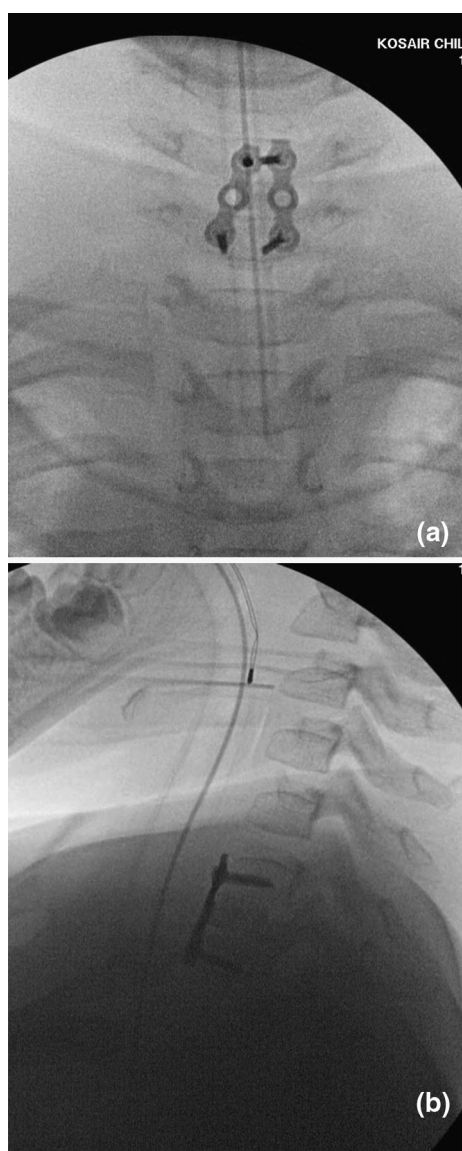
Positioning radiograph with patient in halo crown on radiolucent table
